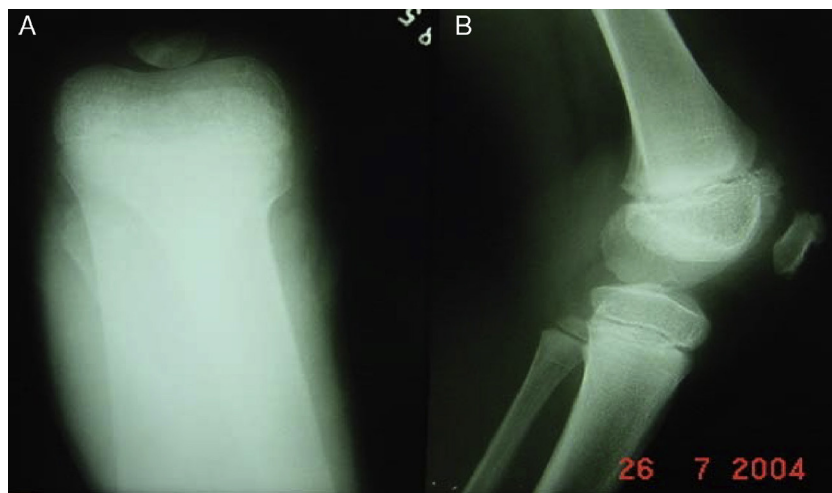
Appearance one year after the operation, on radiographs of the right knee in axial view (A) and lateral view (B), showing adequate growth of the patella.
